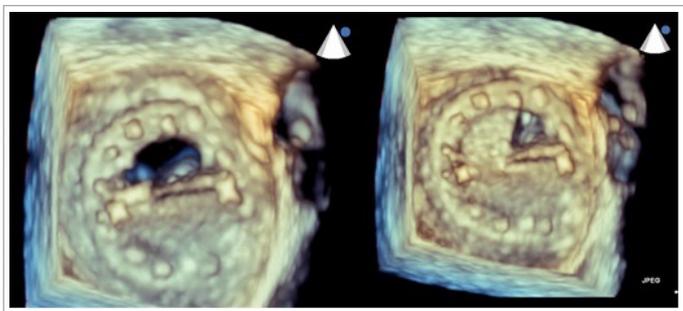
Tridimensional reconstruction during transoesophageal echocardiography, showing prosthetic dysfunction.
